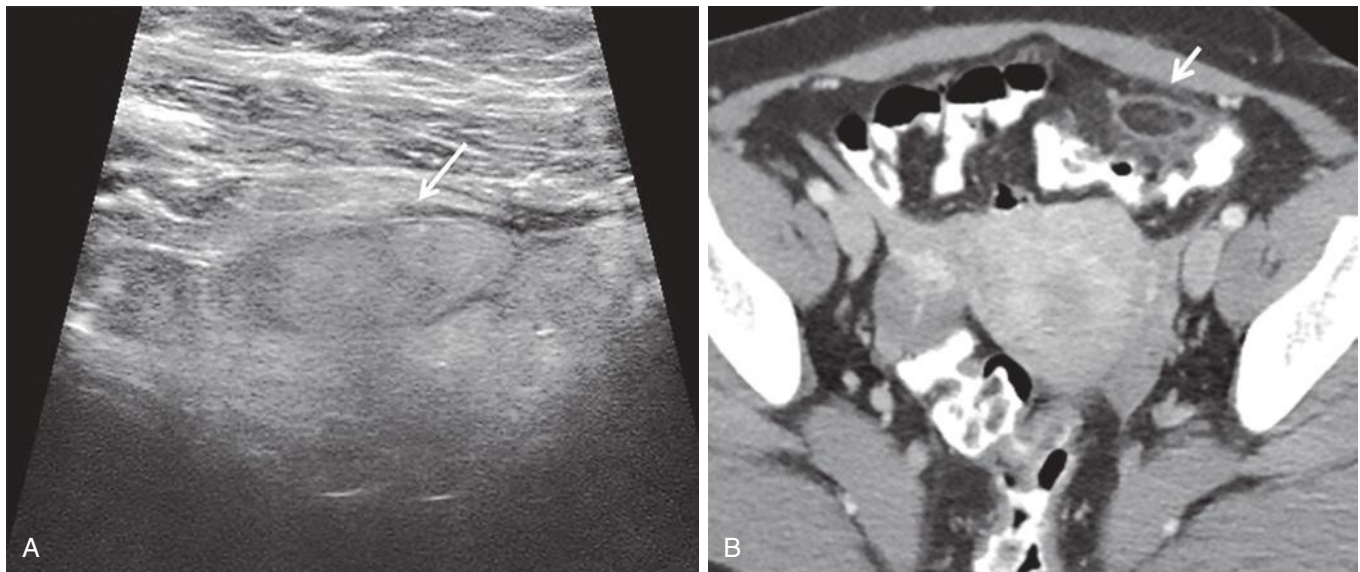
Epiploic appendagitis in patient with left pelvic pain. A, High-resolution linear transducer demonstrates an oval hyperechoic mass-like area (arrow) with hypoechoic rim at the point of maximal tenderness. The uterus and adnexa were normal (not shown). B, Contrast-enhanced axial computed tomography confirms the diagnosis of epiploic appendagitis. Note rim-enhancing fat-attenuation abnormality at the left lower quadrant (arrow).
